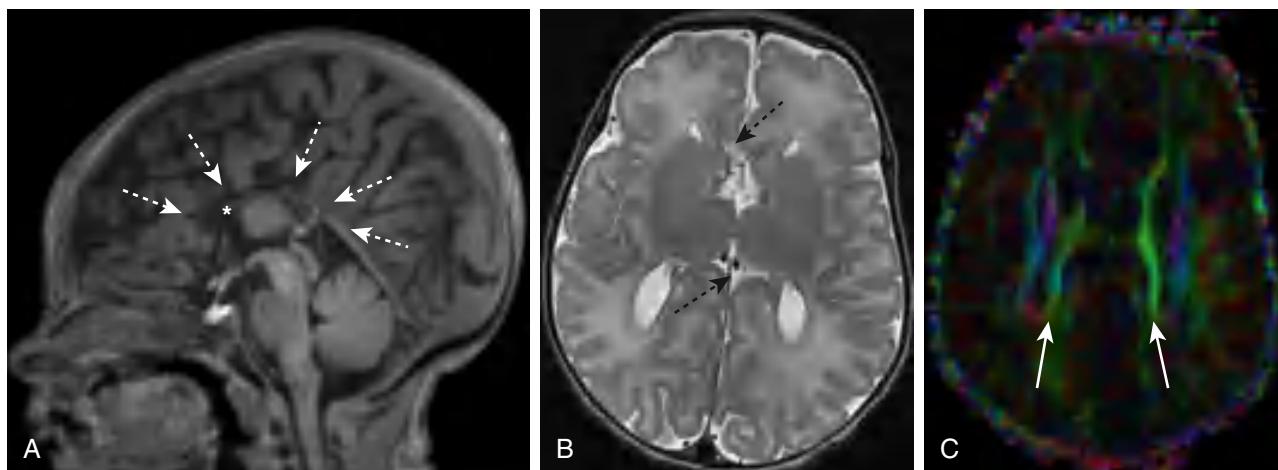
Complete corpus callosum (callosal) agenesis by brain MRI. A, Sagittal T1-weighted sequence of a newborn with callosal agenesis demonstrates lack of a normal corpus callosum (dashed arrows along expected course) with multiple sulci radiating without interruption from the third ventricle (asterisk). B, An axial T2-weighted image of this patient demonstrates a parallel rather than curved course of the lateral ventricles (missing callosal genu and rostrum denoted by dashed arrows). C, Redirection of white matter tracts (Probst bundles) can be directly visualized in callosal agenesis using colored fractional anisotropy maps, where green denotes anteroposterior fiber tracts running parallel to the lateral ventricles rather than crossing the midline.
